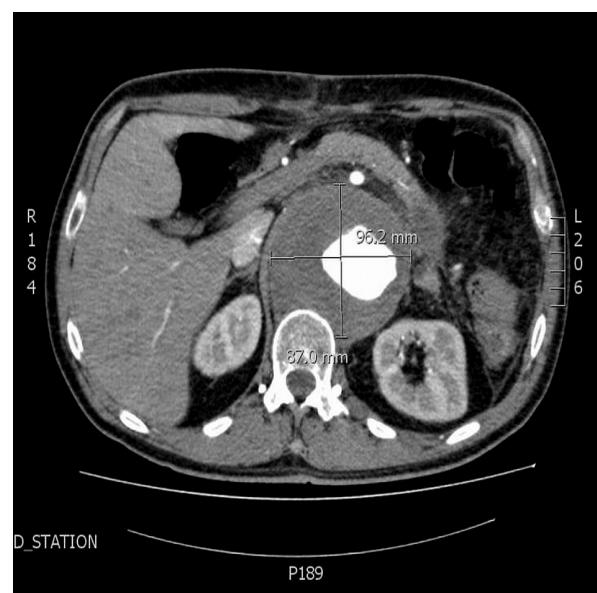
The maximum transverse size the aneurysm reached at the L1 level (angio-CT)
